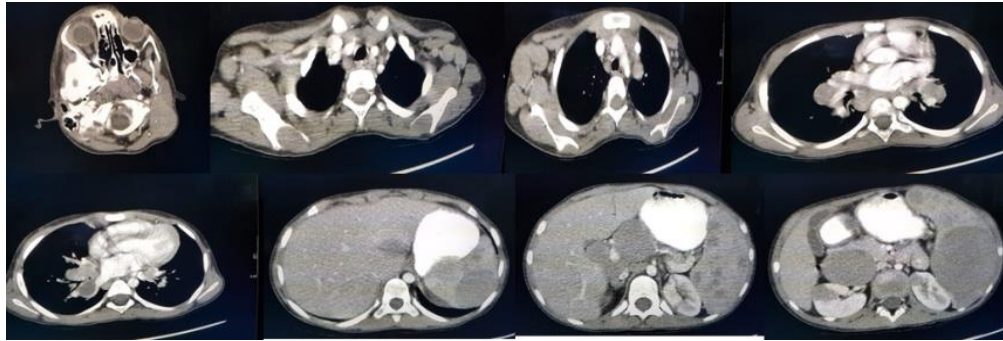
Computed Tomography scan of neck, axillary, chest/mediastinal, abdominal, inguinal in a patient with Kikuchi disease.
